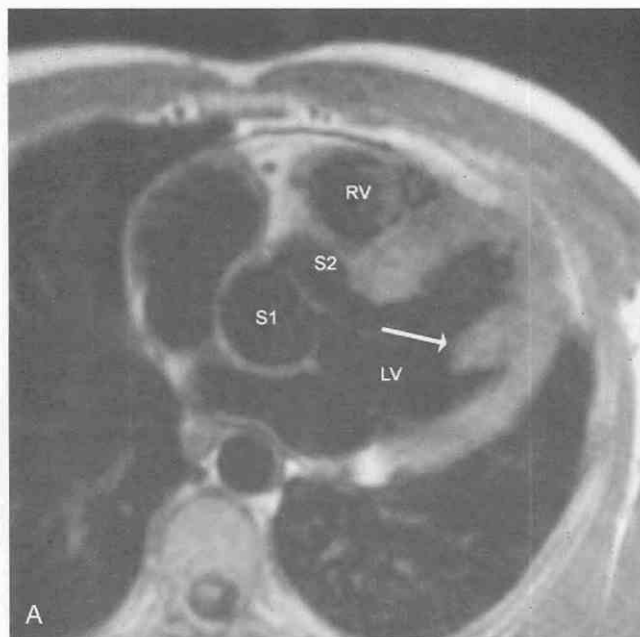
MR images obtained from two adult patients with congenital bicuspid aortic valve disease. A, Axial spin-echo acquisition from a 23-year-old man. Notice the asymmetry of the two aortic sinuses of Valsalva (S1 and S2). The left ventricular (LV) myocardium is thickened; note the severe hypertrophy of the papillary muscle (arrow). RV, right ventricle. B, Systolic short-axis gradient-echo acquisition from a 27-year-old man. There is mild dilatation of the aortic root. The limited valve orifice appears as increased signal intensity sandwiched between the two aortic valve leaflets (arrows). LA, left atrium; RA, right atrium; RV, right ventricle.
